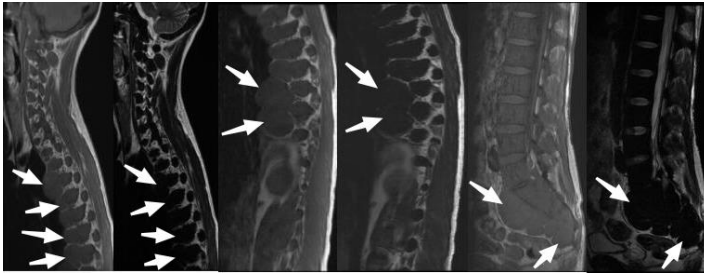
MRI of the whole spine showed multiple well-circumscribed and smoothly-outlined lobulated paraspinal masses (white arrows) with isointensity to muscle on T1WI and hypointensity on T2WI.
